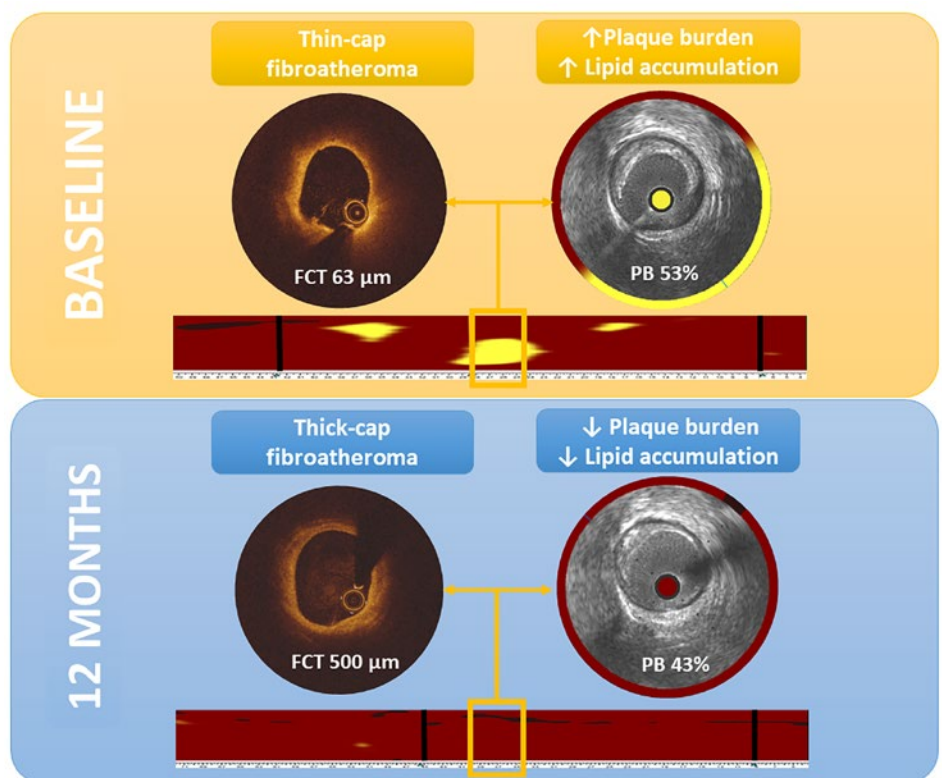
A patient in the PACMAN-AMI trial showing high-risk plaque features at baseline and atheroma volume regression, reduction in lipid content and fibrous cap thickening at the 12-month follow-up. Optical coherence tomography (left) reveals the plaque type and cap thickness; intravascular ultrasonography (right) reveals the plaque burden; and the near-infrared spectroscopy-derived lipid plaque spread-out plot is shown on the bottom. FCT: Fibrous cap thickness; PB: Plaque burden.
